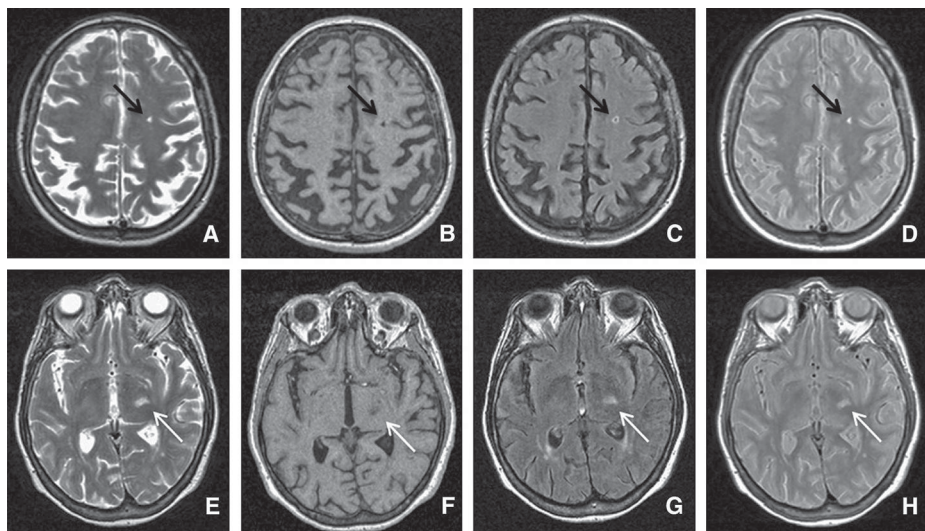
Main signal characteristics used for defining silent brain infarcts (SBIs) on different magnetic resonance imaging (MRI) sequences. (A–D) A silent brain infarct corresponds to a cerebrospinal fluid (CSF) signal on all MRI sequences (black arrows). (A) Axial T2 weighted (T2W) imaging. (B) Axial T1-weighted (T1W) imaging. (C) Axial fluid-attenuated inversion recovery (FLAIR) imaging. (D) Axial proton density (PD) imaging. (E–H) A hyperintense lesion on T2W images that is moderately hypointense on T1 in the left thalamus (white arrows) is not defined as an SBI in studies defining only cavities containing CSF as infarcts, whereas it is diagnosed as an infarct in studies that simply defined hyperintense T2 and hypointense T1 foci as infarcts. (E) Axial T2W. (F) Axial T1W. (G) Axial FLAIR. (H) Axial PD. (Adapted with permission from Zhu et al. *Stroke*. 2011;42:1140–1145.)
